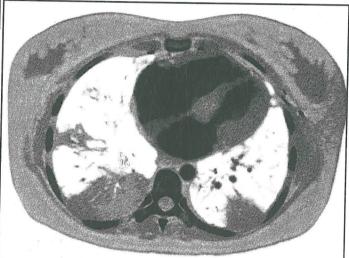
CT Scans showing the left ventricular myxoma causing inflow obstruction and thickening of the ventricular septum and basal walls.
